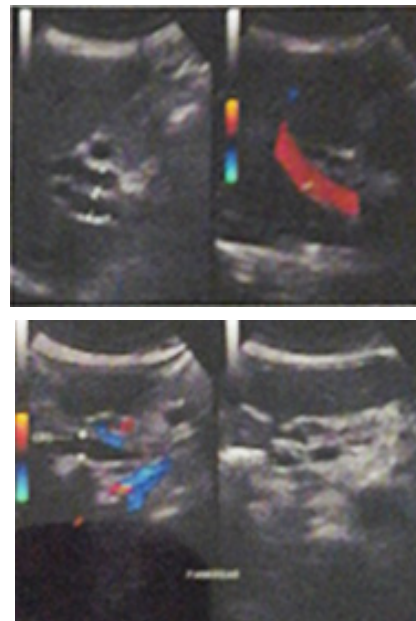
Abdominal ultrasound showed hepatomegaly, dilatation of intra and extra hepatic bile duct and the pancreatic duct which was suspected caused by an obstruction in the distal common bile duct (CBD) (due to mass with strictures as the differential diagnosis)
